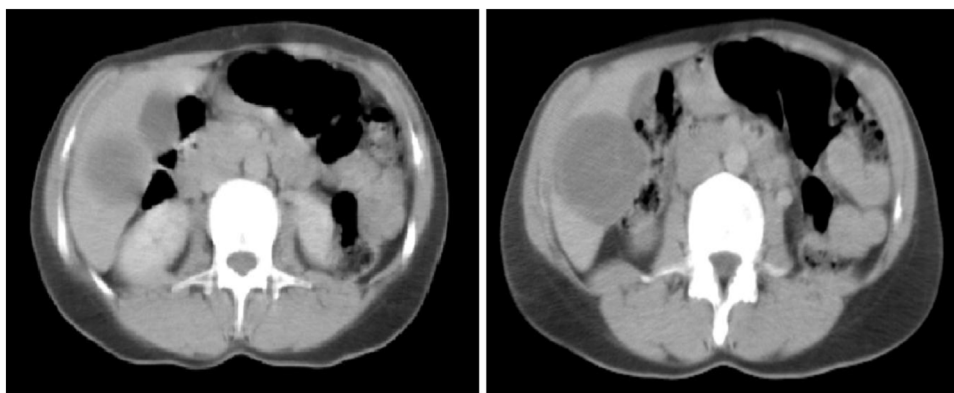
Abdominal CT shows liver hydatid cyst in the VI segment.
